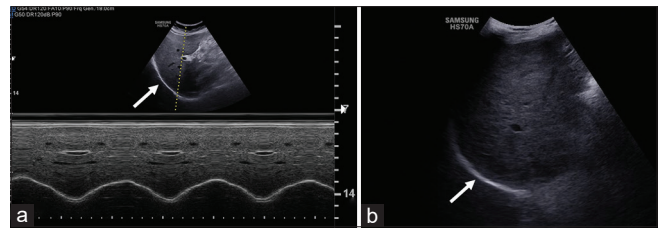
Ultrasound images on diaphragm (arrow). (a) M-Mode scan done at the midclavicular line to assess diaphragmatic motility. (b) B-Mode acquisition shown here as a still from cine-loop image obtained to measure diaphragmatic excursion
